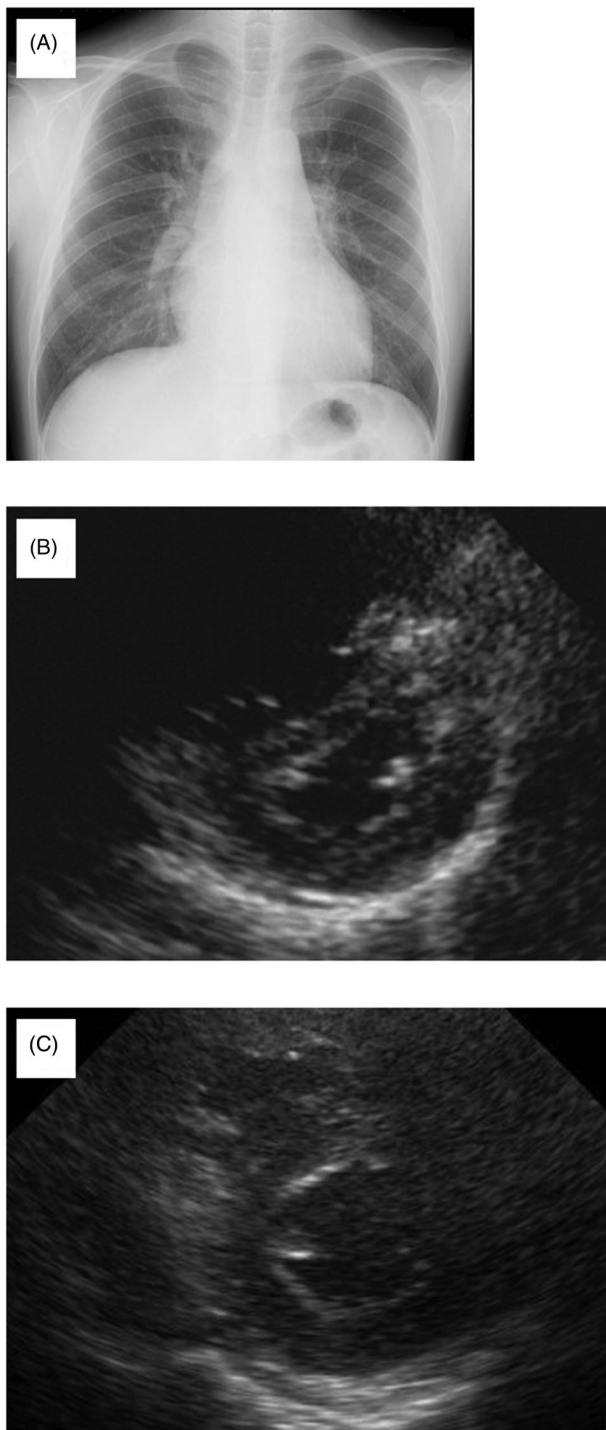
Chest X-ray (A) examination showed enlargement of the bilateral pulmonary artery. Transthoracic echocardiography (B) showed the compressed left ventricle in a D shape, which improved 7 years later (C).
